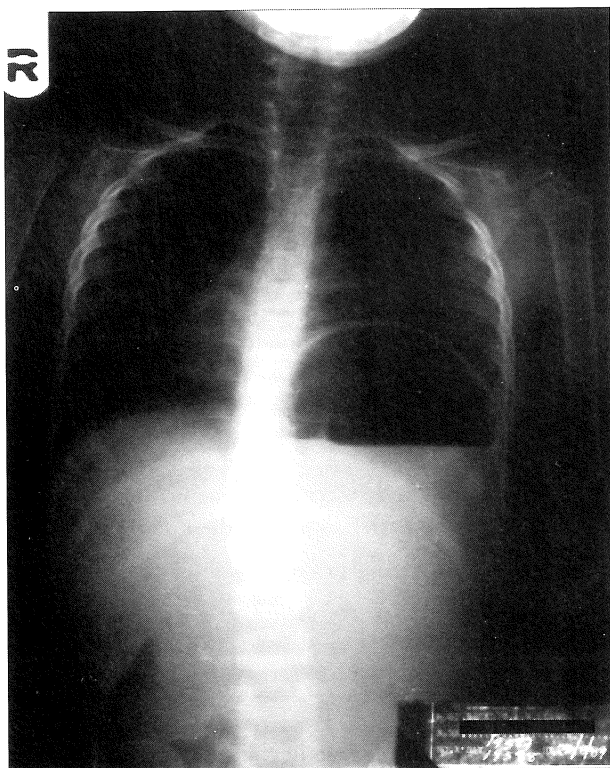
Plain X-ray of the abdomen. An inverted stomach with an air fluid level beneath an elevated left hemidiaphragm.
